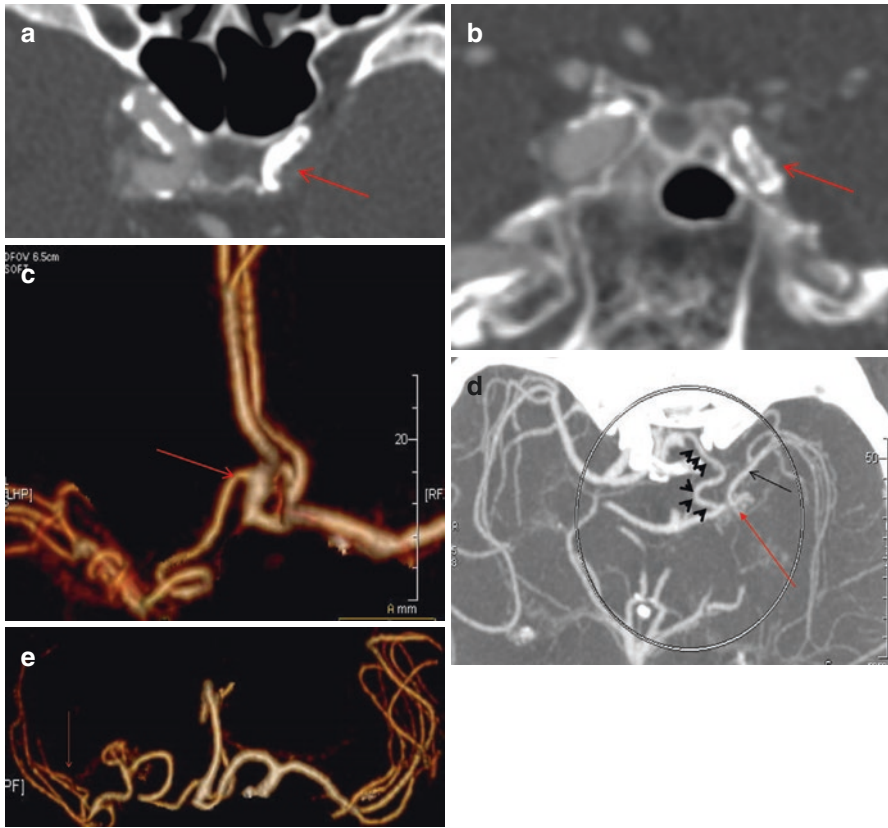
(a) Axial CT image at the level of cavernous carotids shows occlusion of the left ICA (*red arrow*), due to atherosclerotic disease (Reproduced from Zampakis et al. [6]). (b) Coronal reconstruction at the level of cavernous carotids verifies the occlusion of the left ICA (*red arrow*), as well as the atherosclerotic disease (Reproduced from Zampakis et al. [6]). (c) CTA (VRT 3D reconstructions) shows the accessory MCA as a vessel coming from the A2 segment of ipsilateral anterior cerebral artery (*red arrow*) (Reproduced from Zampakis et al. [6]). (d) Axial MIP image shows the course of AccMCA (*black arrowheads*), the anastomotic network (Moya-Moya type) at the level of left mid M1 segment (*red arrow*), as well as the patent peripheral left MCA (*black arrow*) (Reproduced from Zampakis et al. [6]). (e) CTA (VRT 3D reconstructions) reveals the same configuration and patent peripheral MCA (*red arrow*) (Reproduced from Zampakis et al. [6])
